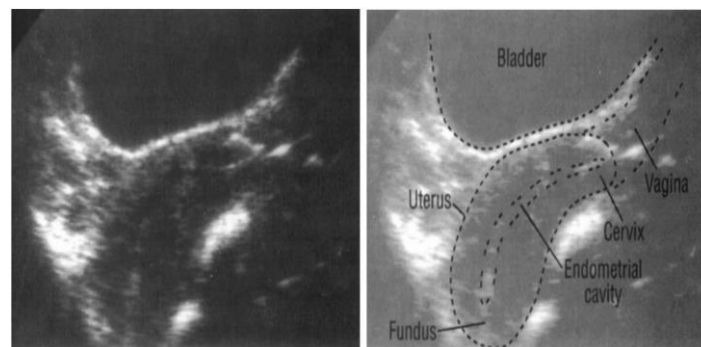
Sagittal TA ultrasound showing a retroverted uterus (Palmer P.E.S et-al 2003)
